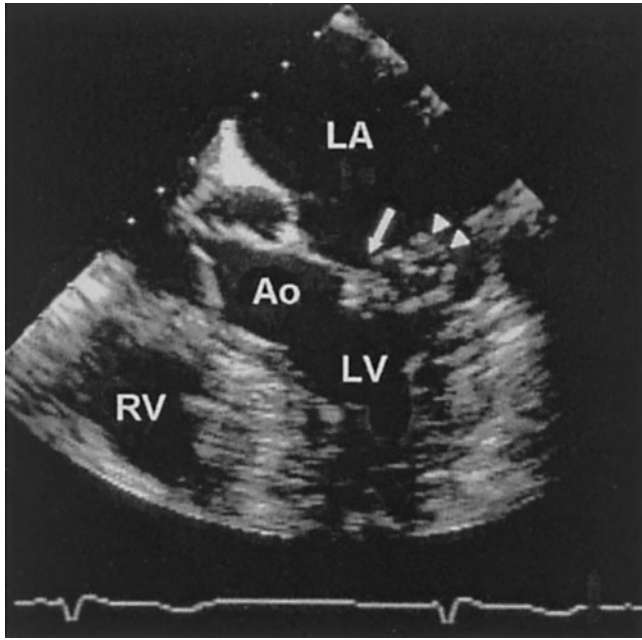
Morphologic examination of organic mitral regurgitation in transesophageal echocardiography. The patient presents with a flail posterior leaflet imaged in a long-axis view. The long arrow shows the ruptured chorda of the posterior leaflet. The arrowheads show the flail segment of P_2 . Ao = aorta; LV = left ventricle; LA = left atrium; RV = right ventricle.
